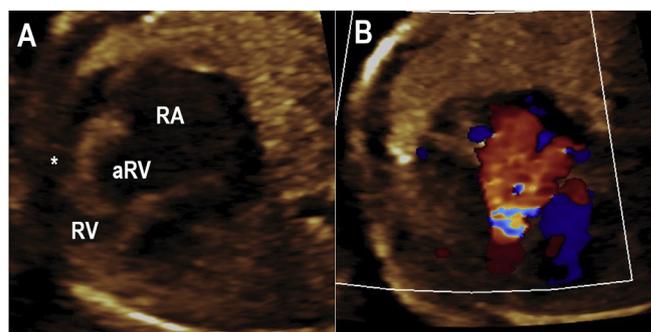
Panel A: Fetal echocardiogram of Ebstein anomaly at 22 4/7 weeks gestational age with severe inferior displacement of the tricuspid valve into the right ventricle (RV) resulting in a large portion of atrialized right ventricle (aRV) and dilated right atrium (RA). A small pericardial effusion (*) is also noted. Panel B: the severe displacement of the tricuspid valve is associated with severe tricuspid regurgitation that has resulted in RA dilation.
